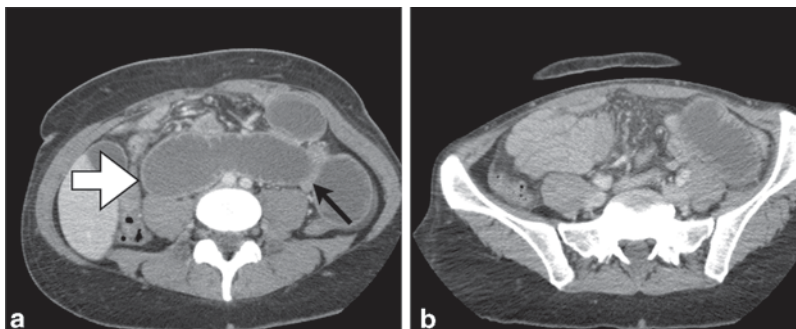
Small bowel obstruction secondary to internal herniation and volvulus around jejunostomy tube site. a Abdominal CT depicting dilated loops of small bowel (white arrow) as well as a decompressed loop of small
